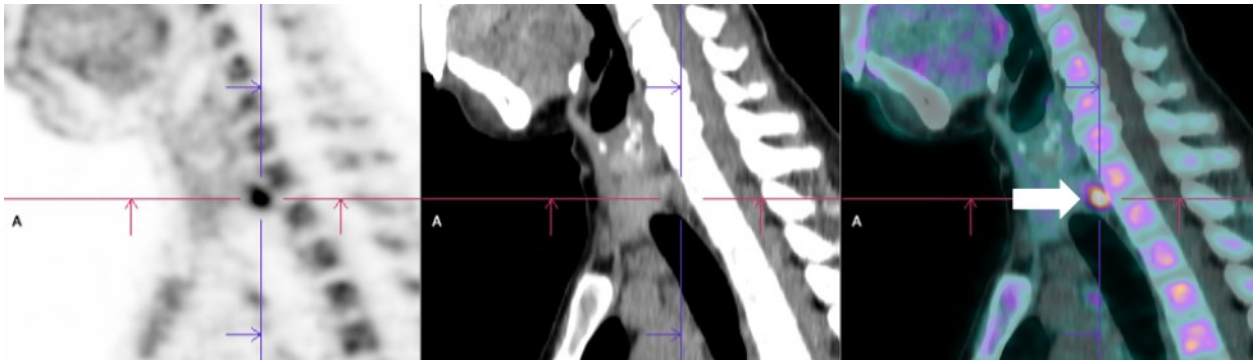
Sagittal PET/CT images of the neck and upper chest showed a focal increased FCH uptake inferoposterior to the right thyroid lobe at the tracheoesophageal groove with SUV of 7.9 (white arrow), suggestive of parathyroid adenoma.
